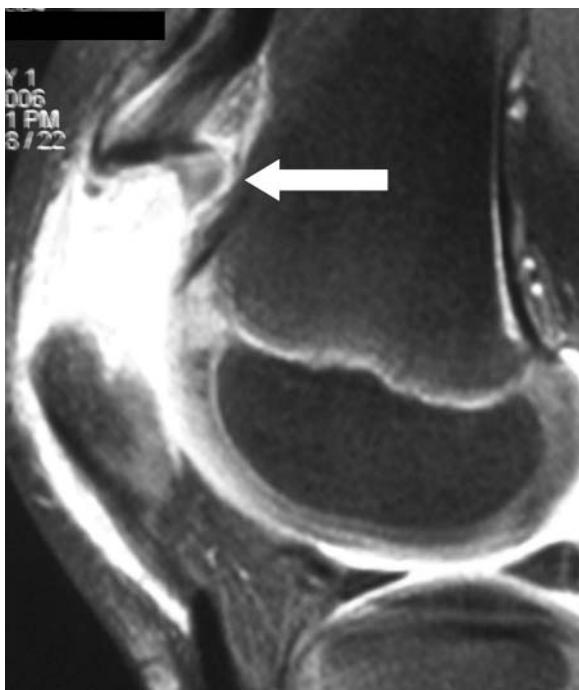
Sagittal T2-weighted magnetic resonance image. Arrow points to superior avulsed cartilage attached to periosseal sleeve.
